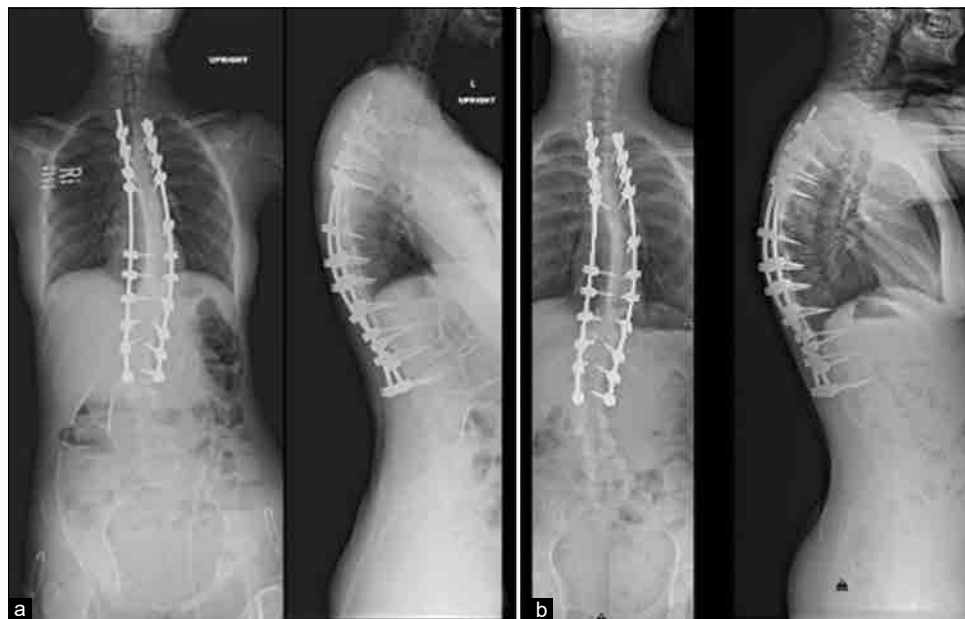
Standing thoracolumbar radiographs immediately (a) and 2-year postoperative (b) demonstrating significant improvement in patient's coronal deformity as well as restoration of a physiologic sagittal alignment.
